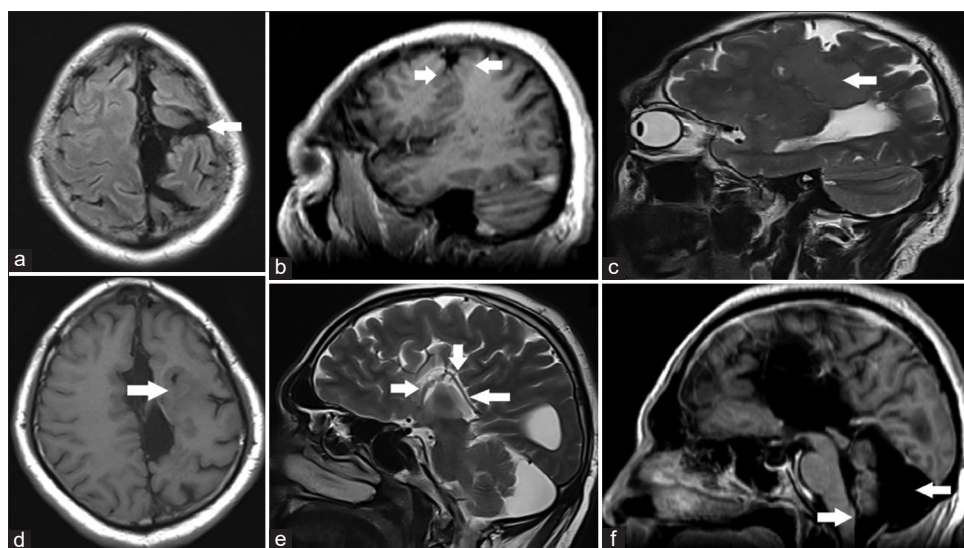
Multiple congenital abnormalities seen in MRI marked with white arrows. (a) Open lip schizencephaly, (b) polymicrogyria, (c) hetero-trophic grey matter in left fronto-parietal region, (d) focal cortical dysplasia, (e) corpus callosum agenesis, and (f) Dandy-walker malformation
